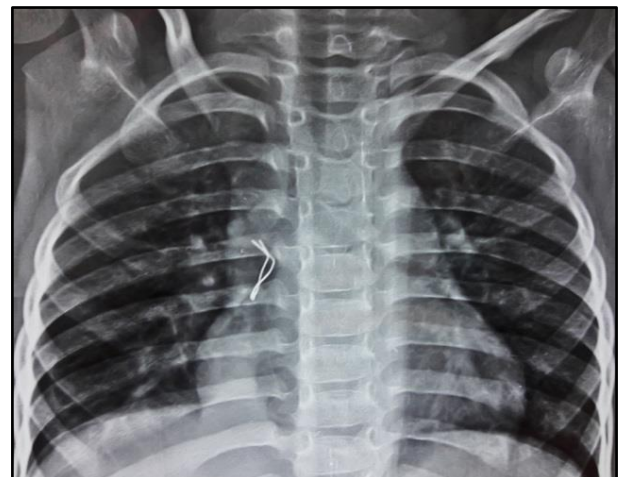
Showing X-Ray Chest Showing Twisted Wire like Shadow
